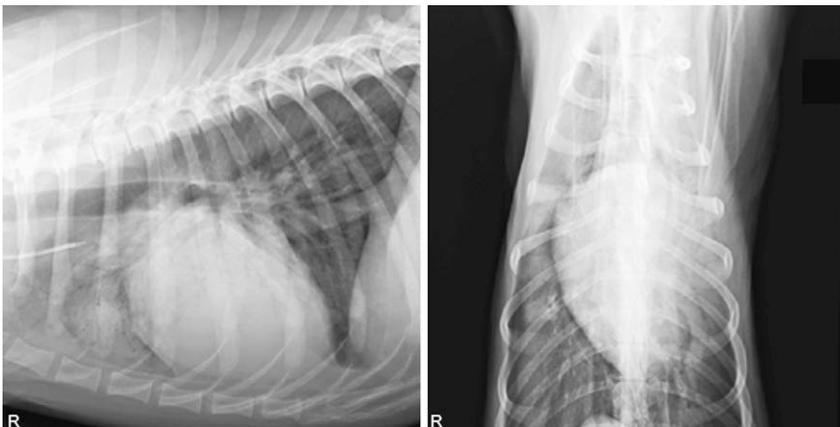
Orthogonal thoracic radiographs of an 8-year-old, intact, male poodle with pneumonia. Note the cranioventral distribution of the increased opacity, which is worse on the left.
